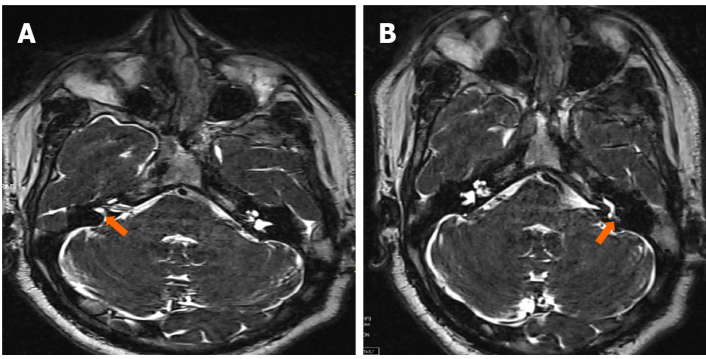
Labyrinthitis. A: The axial 3D-constructive interference in a steady state (CISS) magnetic resonance image showing focal signal loss in the vestibule (orange arrow) on right side; B: The axial 3D-CISS magnetic resonance image showing focal signal loss in the horizontal semicircular canal (orange arrow) on left side.
